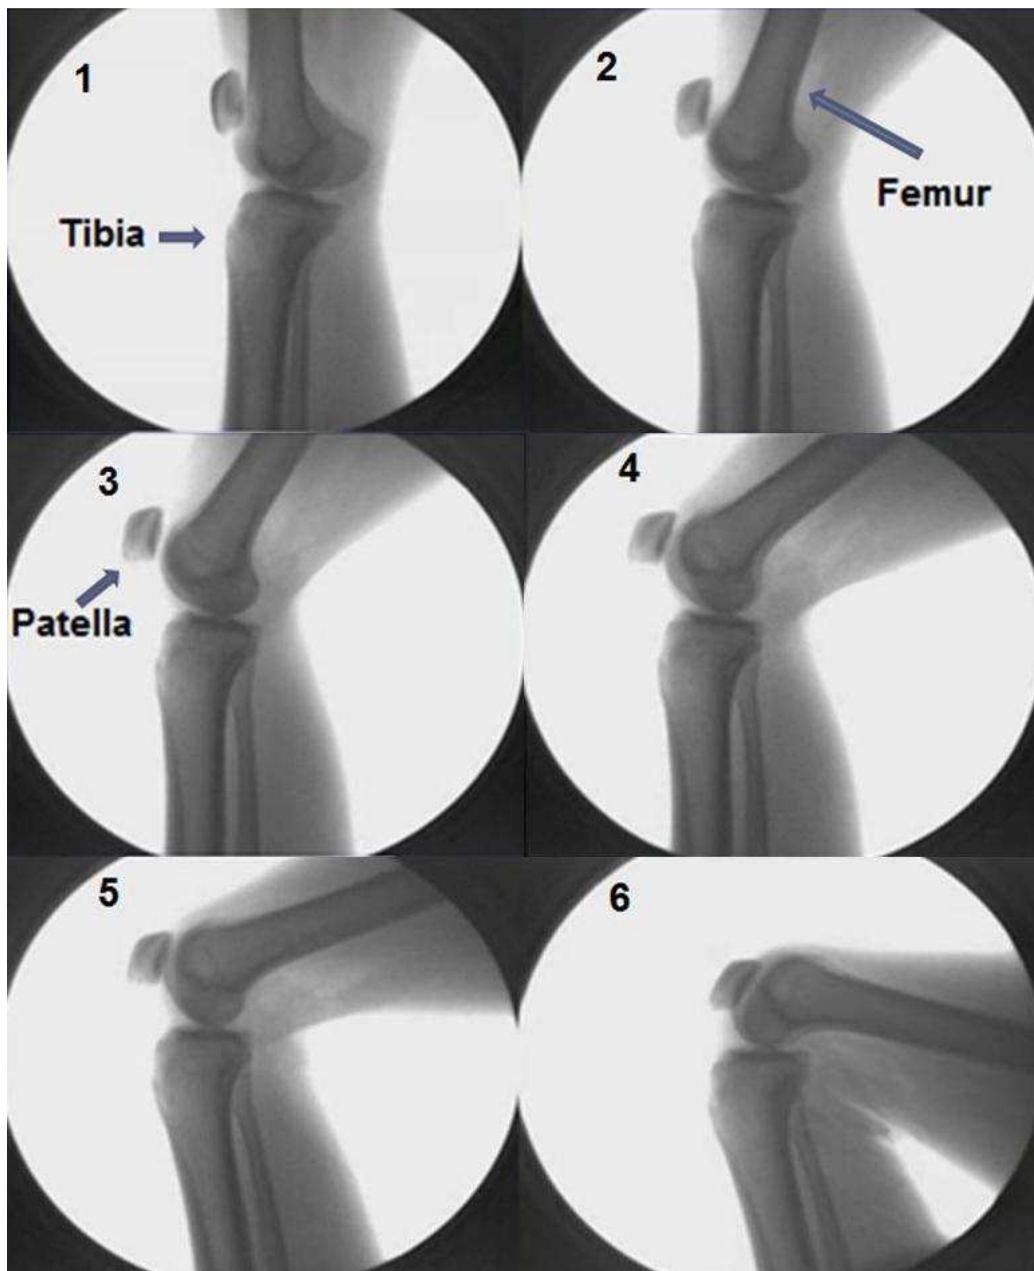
Fluoroscopic images of a volunteer's knee [26] at different flexion angles starting from full extension (1) to deep knee bend (6). The images show the different articular bone surfaces of the knee visible to ultrasound at different flexion angles
